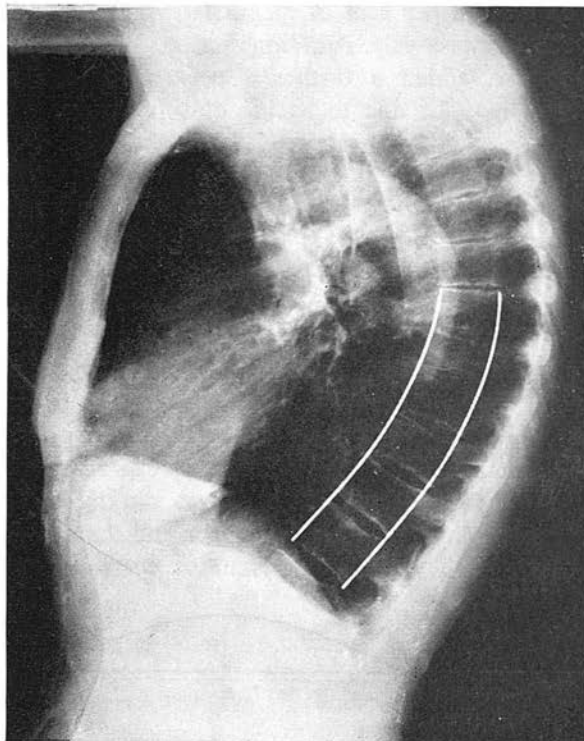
Dimensions of a lateral chest radiograph to estimate index of wedging (of vertebral bodies)
